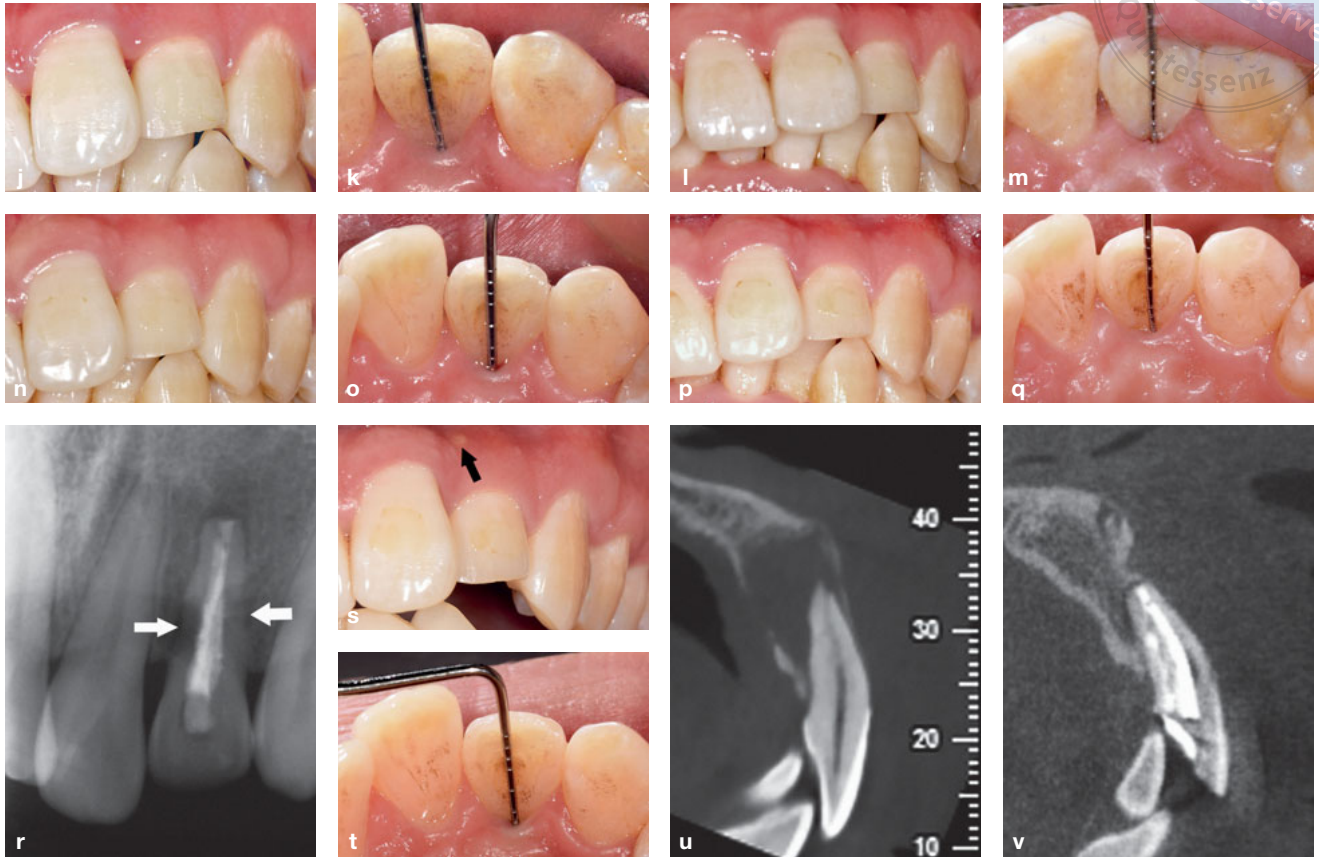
(cont.) (j) and (k) Clinical photographs taken at 3-month follow-up. (l) and (m) Clinical photographs taken at 6-month follow-up. (n) and (o) Clinical photographs taken at 12-month follow-up. (p) and (q) Clinical photographs taken at 18-month follow-up. (r) Postoperative radiograph taken at 24-month follow-up. External root resorption of the coronal and middle third of the root was detected at 24 months (white arrow). (s) A draining sinus tract was again detected on the labial gingiva (black arrow). The gingival margin position and gingival papilla were well preserved. (t) The mid-palatal probing depth was 2 mm. (u) Preoperative CBCT image (sagittal view) and (v) CBCT image taken at 24-month follow-up (sagittal view). The extensive bone defect was almost repaired.
